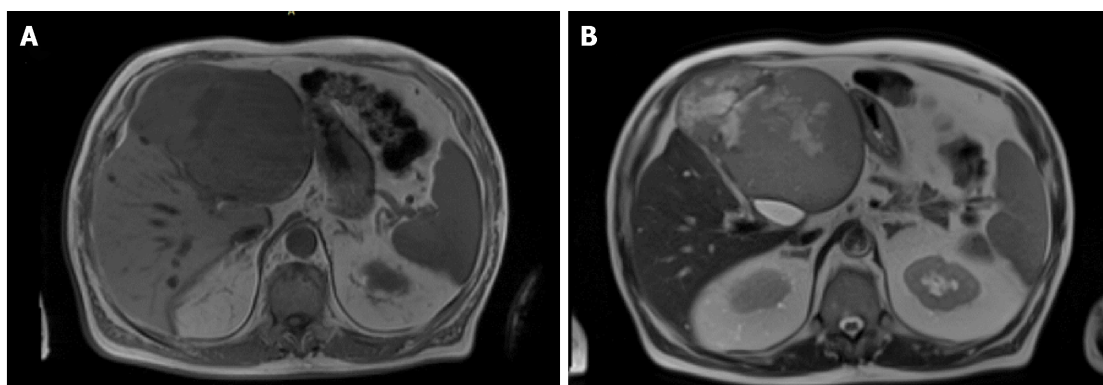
Abdominal magnetic resonance imaging displaying the left liver mass. A: T1. B: T2.
